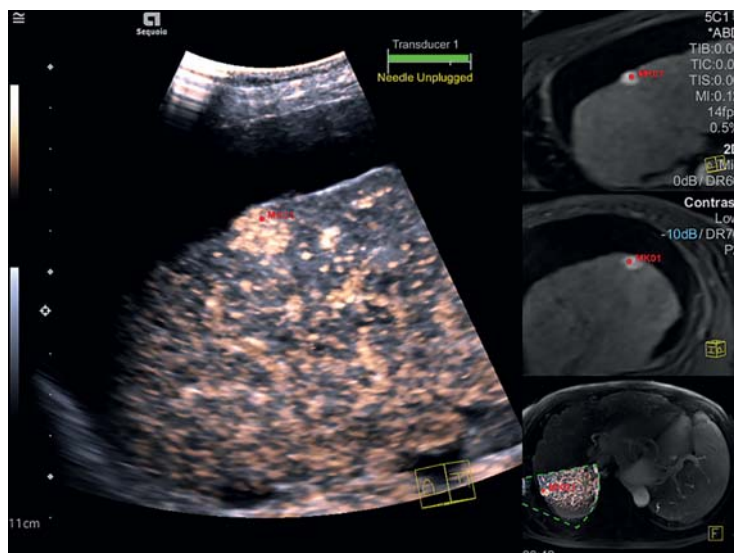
On the contrast enhanced MRI scan, a suspect liver lesion is visible (red marker) in a cirrhotic liver. In the same position and with a comparable size, this lesion shows increased early arterial contrast medium absorption on ultrasonography. MRI morphologically and sonographically the finding is consistent with a hepatocellular cancer about 1 cm in size.
